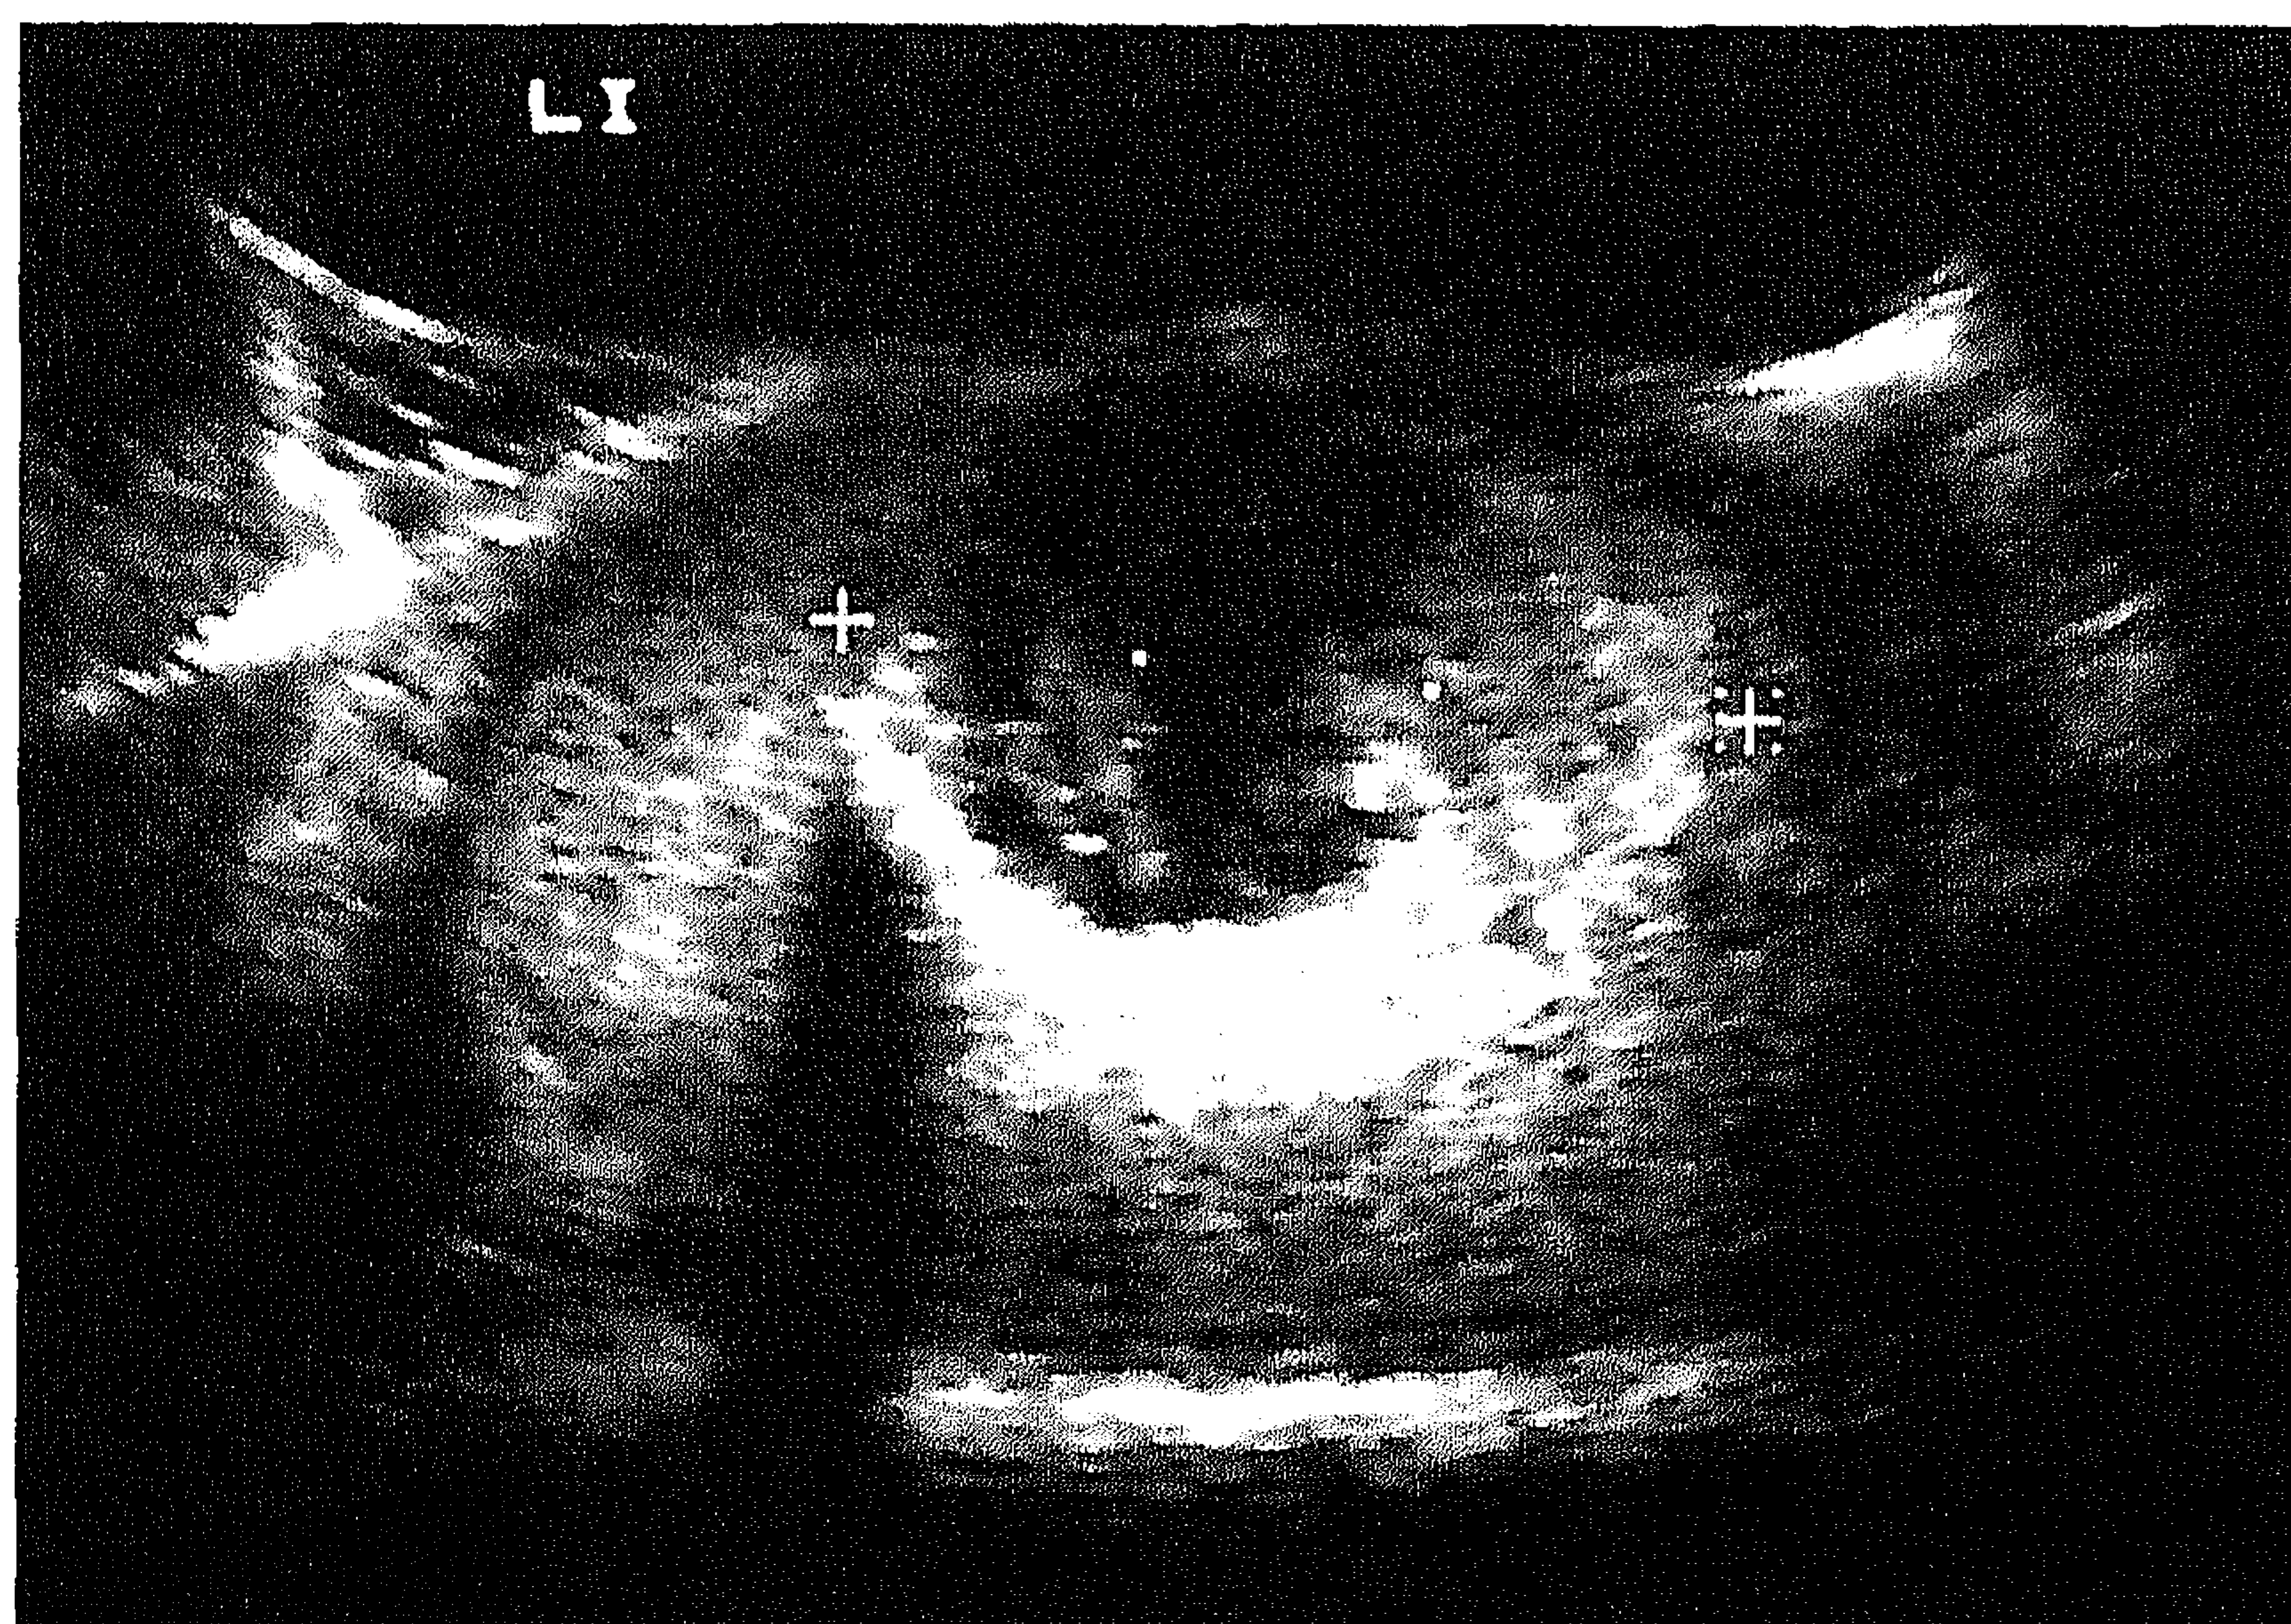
Scrotal ultrasonogram showing a testicular tumour 3 cm in diameter.
